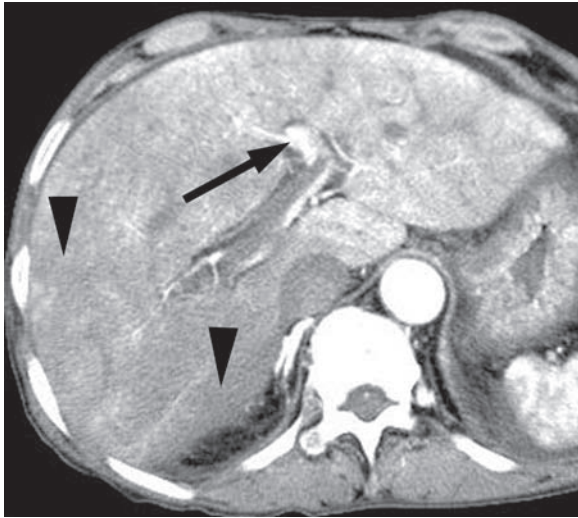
Acute IVC obstruction in a 77-year-old man. Arterial phase CT scan shows a central patchy area with poor enhancement of the peripheral areas of the liver (arrowheads) due to portal venous blood flowing away from the liver (arrow). The obstruction of the IVC was caused by hepatocellular carcinoma (not shown).
